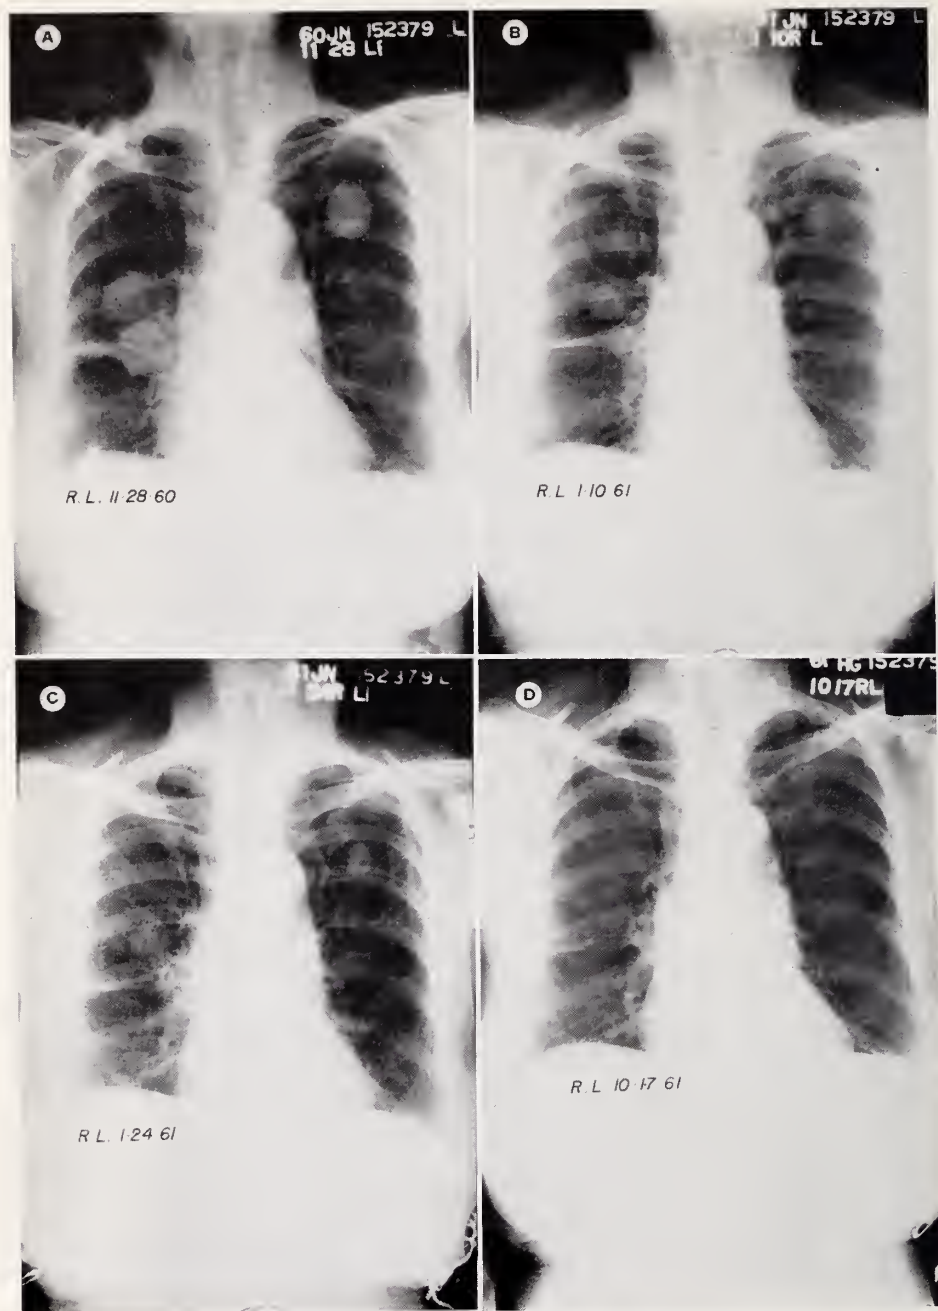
Serial chest roentgenograms showing rapid regression of multiple pulmonary metastases after priming and maintenance thio-TEPA simultaneous with 2 courses of Methotrexate therapy (see case summary #1 for details).
